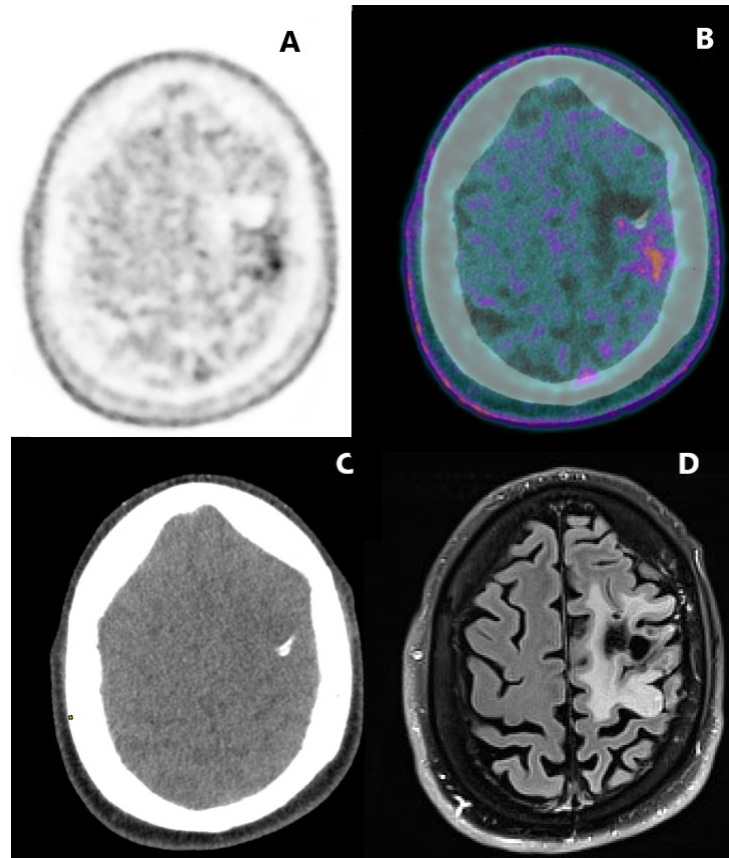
Comparison of the visualizing performance of diagnostic methods. Relapse of oligoastrocytoma WHO grade 4 in a 56-year-old male patient after two surgical treatments for 13 and 5 years and radiochemotherapy for 11 months. On PET/CT (A,B), the metabolic active lesion between the postcentral gyrus and the supramarginal gyrus of the left parietal lobe is characterized by an inhomogeneous accumulation of tracer with accentuation in its lateral-dorsal part. Ventral and medial located zones with practically minimal accumulation of tracer correspond to the area of surgical intervention. On CT (C), a metal clip is detected. On MRI (D), an extensive area of hyperintense signal on T2-FLAIR-sequence in the left parietal lobe was interpreted as postradiation edema or TRC.
